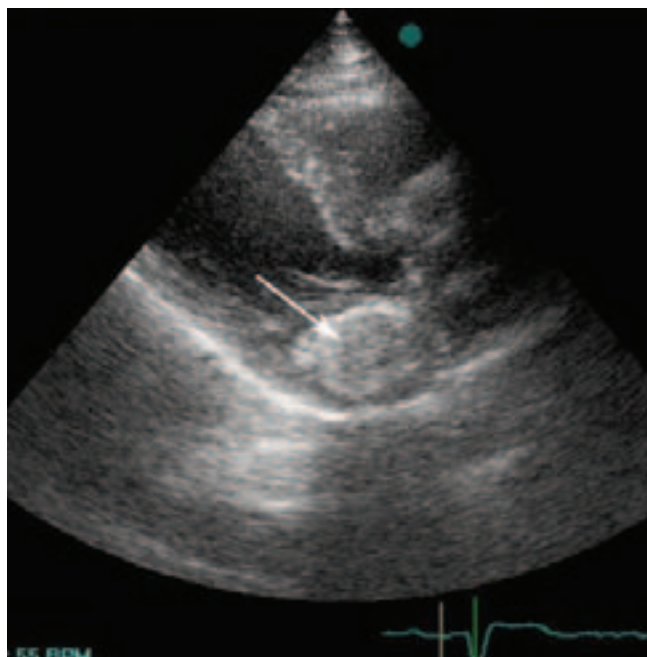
Lipoma; parasternal long-axis view showing a very large encapsulated mass in the left atrioventricular groove (arrow)
